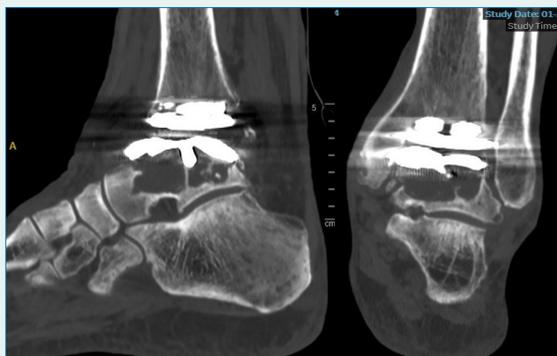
Pre-op CT scan of painful Left TAR with bone loss
